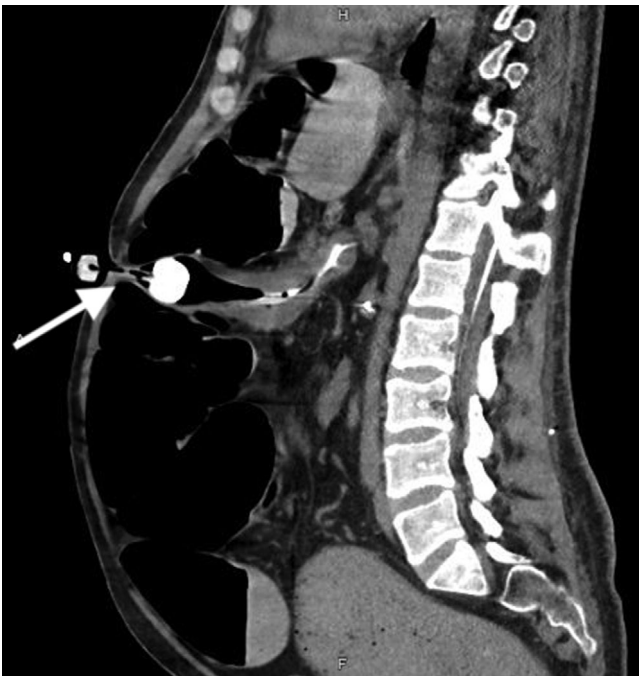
Sagittal computed tomography (CT) imaging of the abdomen demonstrates colonic dilation with air fluid levels and an intact gastric-jejunostomy (GJ) tube (arrow)
